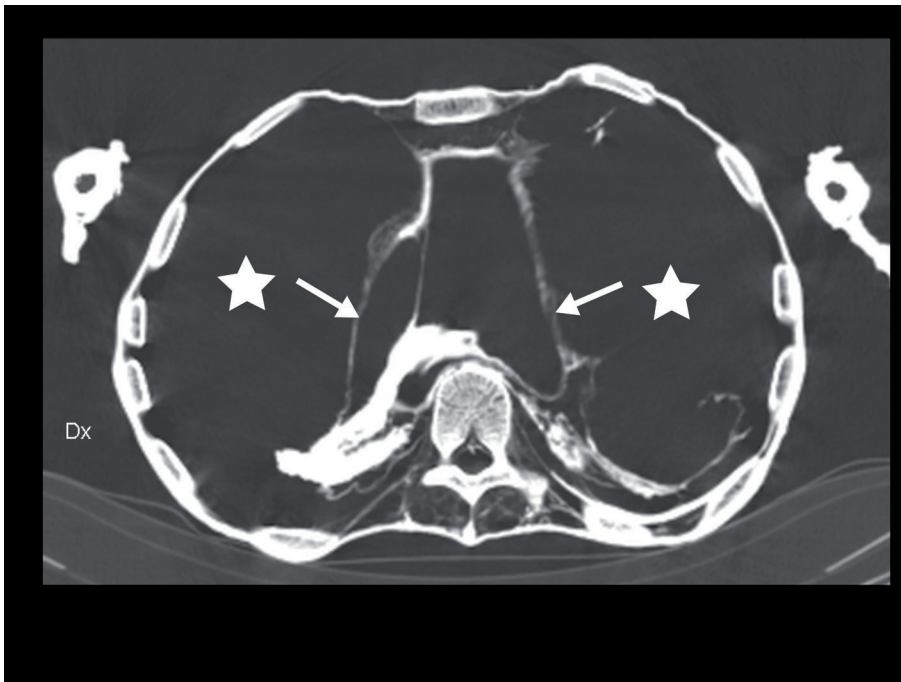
Axial CT image of the lower thoracic region of unknown man E. Thorax is filled with air (stars) and appears to be inflated. Residue in the diaphragm and organs (arrows) are present at the dorsal site
